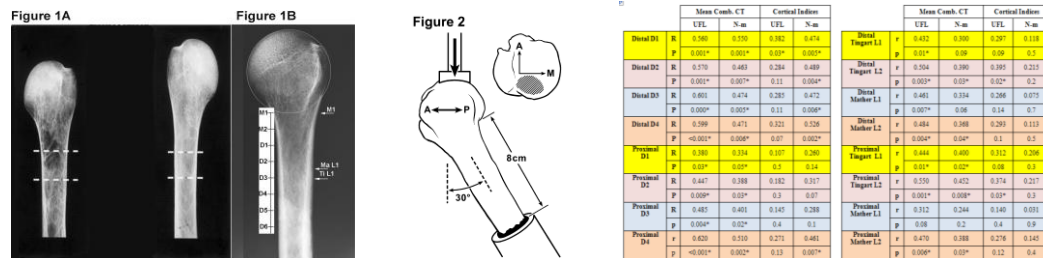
AP radiographs of proximal humeri from Tingart et al. [2]; Figure 1B: Ti = Tingart; Ma = Mather; L1 = Level 1; M1 = our method’s first metaphyseal level at the lower-most (transversely tangential) edge of the best-fit circle.
